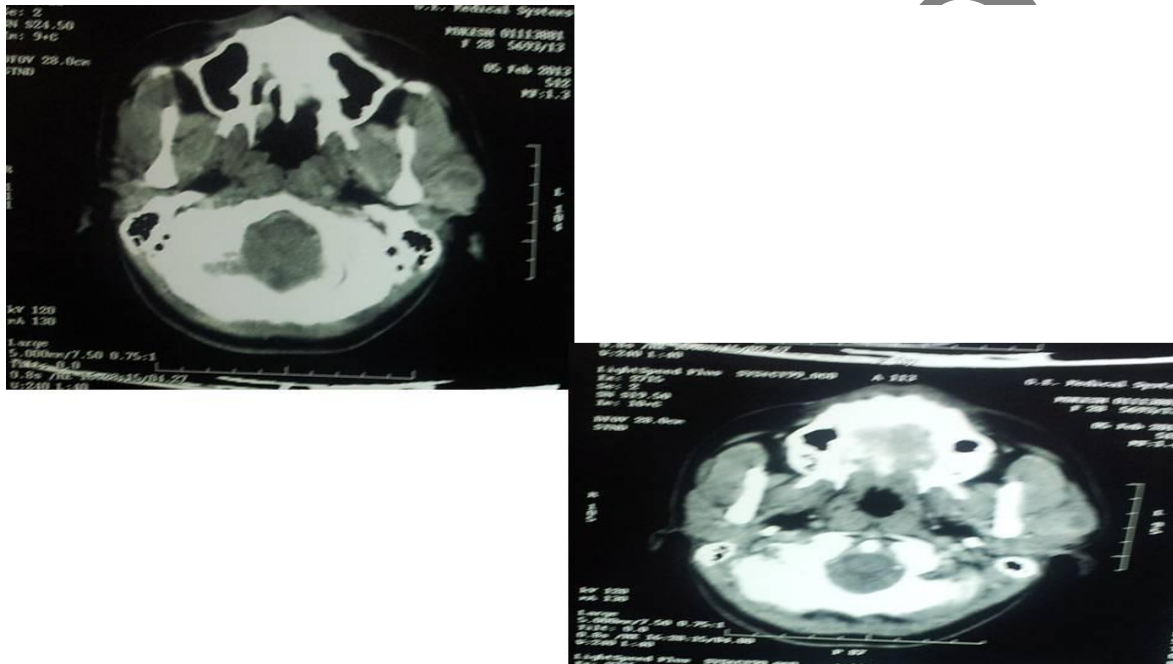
Contrast enhanced CT scan of neck showing well defined mass swelling in the superficial lobe of parotid gland with central area of hypo density
